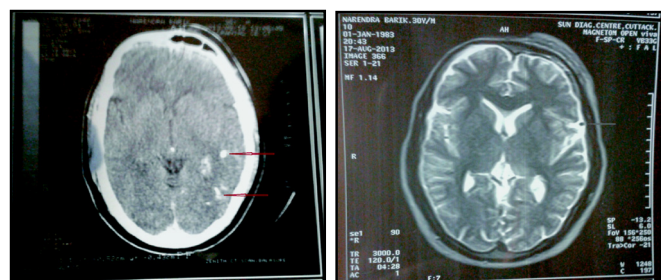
MRI of brain revealed a vascular malformation over left parietal cortical vein along with calcifications over left parieto occipital lobe
